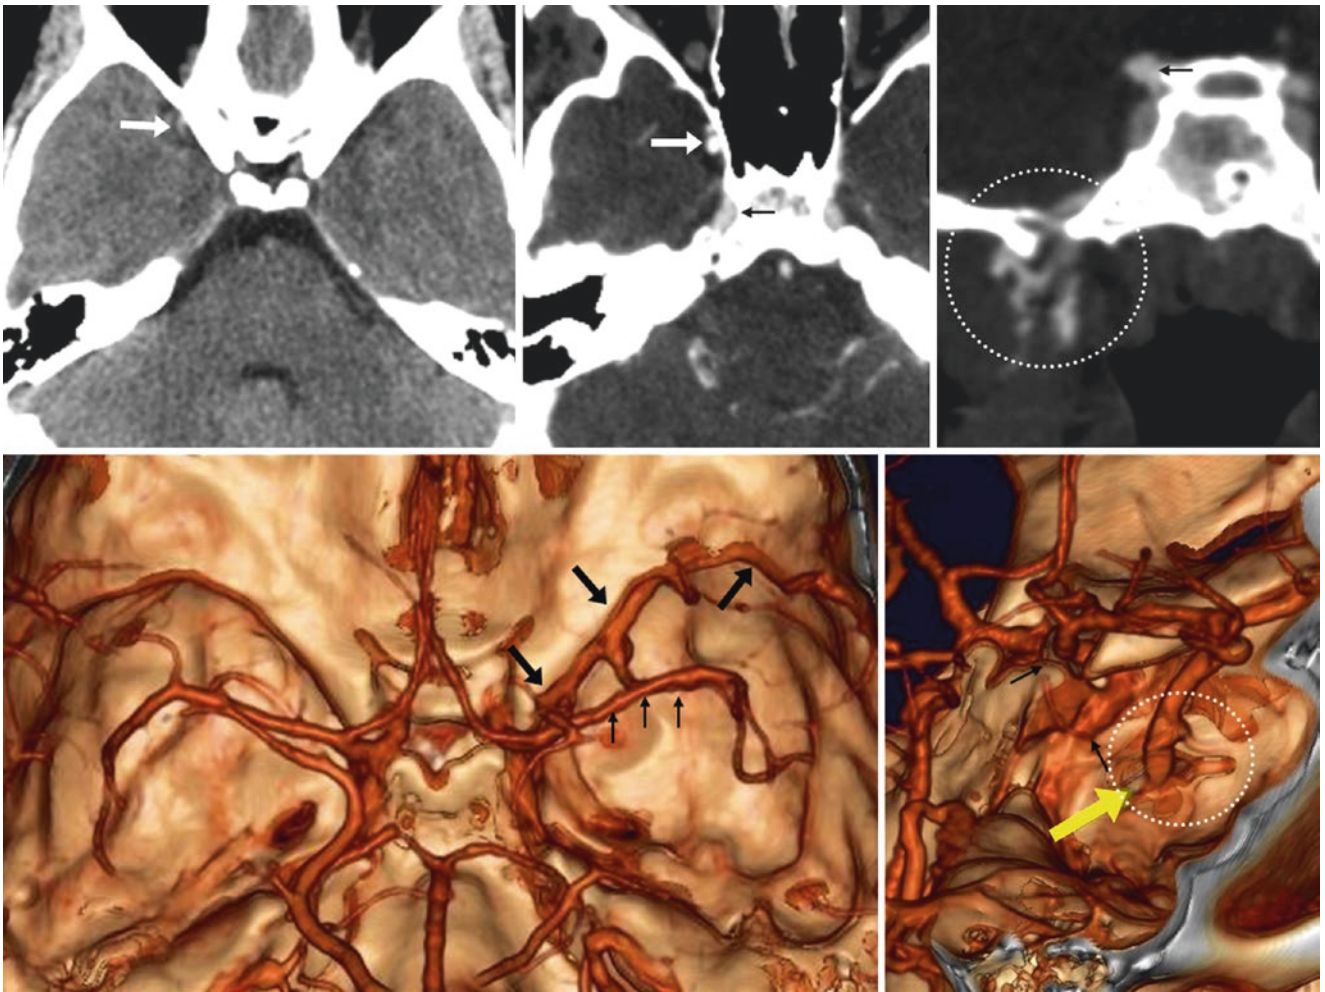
Top row:* 19-year-old with a focal hyperdensity (*arrows*) from an SPS that mimics an aneurysm on nonenhanced CT (*left*); it drains inferiorly on a CTA in axial (*middle*) and coronal (*right*) MPRs. *Bottom row:* A 3D VR superior view (*left*) delineates the SPS (*arrows*)
